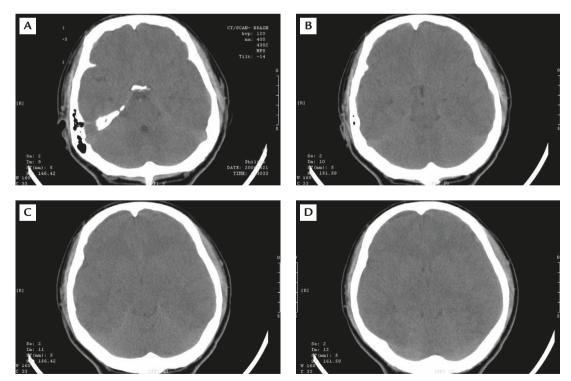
Serial axial computed tomography images of the brain show bilateral subdural hematomas, small size of the ventricular system and obliteration of the basal cistern. The latter 2 findings of spontaneous intracranial hypotension mimic those of increased intracranial pressure.
